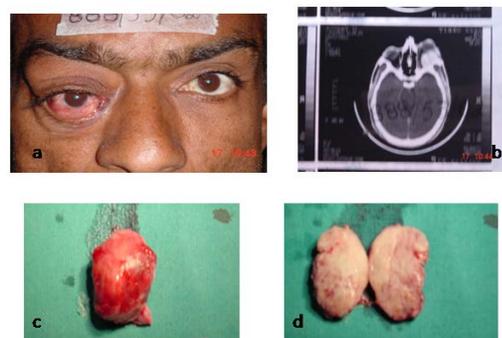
(a) Preoperative picture of a case of schwannoma; (b) CT scan and (c) and (d) Tumour removed after lateral orbitotomy.
